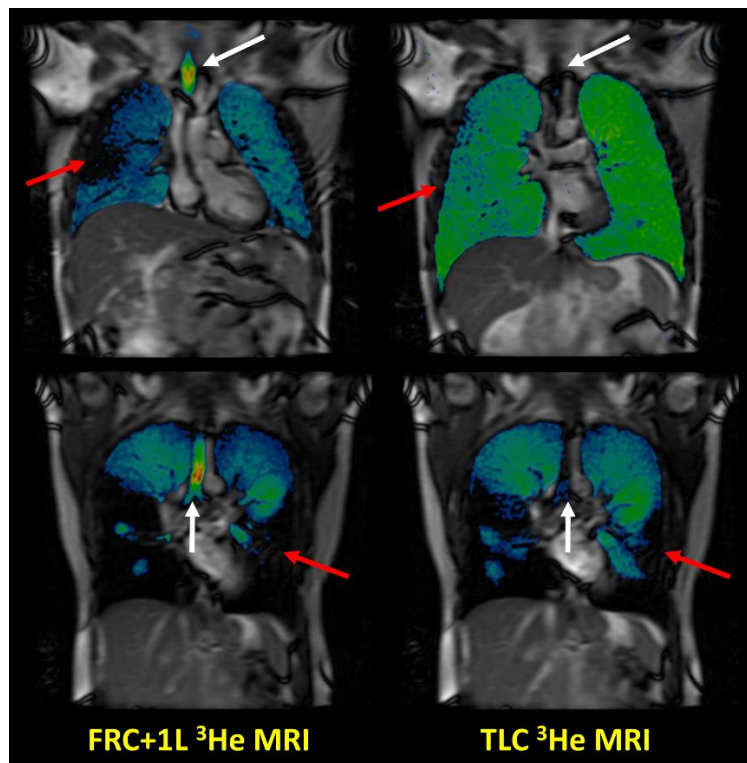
Corresponding coronal slices of patient 1 (top) and 2 (bottom) showing ^3He MRI acquired at FRC+1L (left) and TLC (right) fused with same-breath anatomical ^1H MRI. Several ventilation defects observed at FRC+1L resolve at TLC (red arrows). Similarly, a marked reduction in trachea gas depositions of ^3He can be observed at TLC (white arrows), indicating increased airway opening at the higher inflation state.
